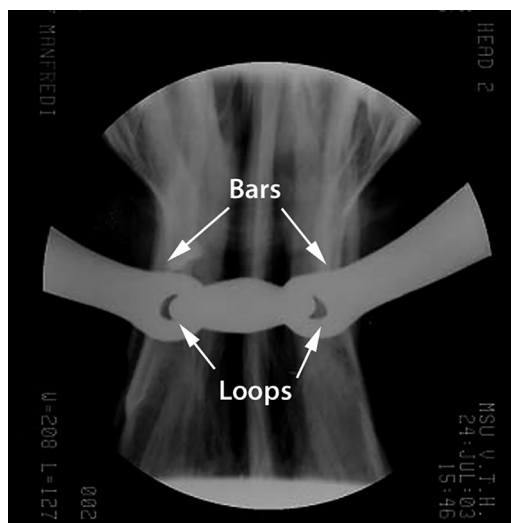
Dorsoventral radiograph showing the relationship between the mouthpiece of a double-jointed bit and the bars of the mandible. Note the canons of the mouthpiece extending laterally on either side of the bars. The bars are separated from the lip commissures by a distance of several centimetres³¹ due to the intervening fleshy cheeks and narrowing of the mandible in this area.
